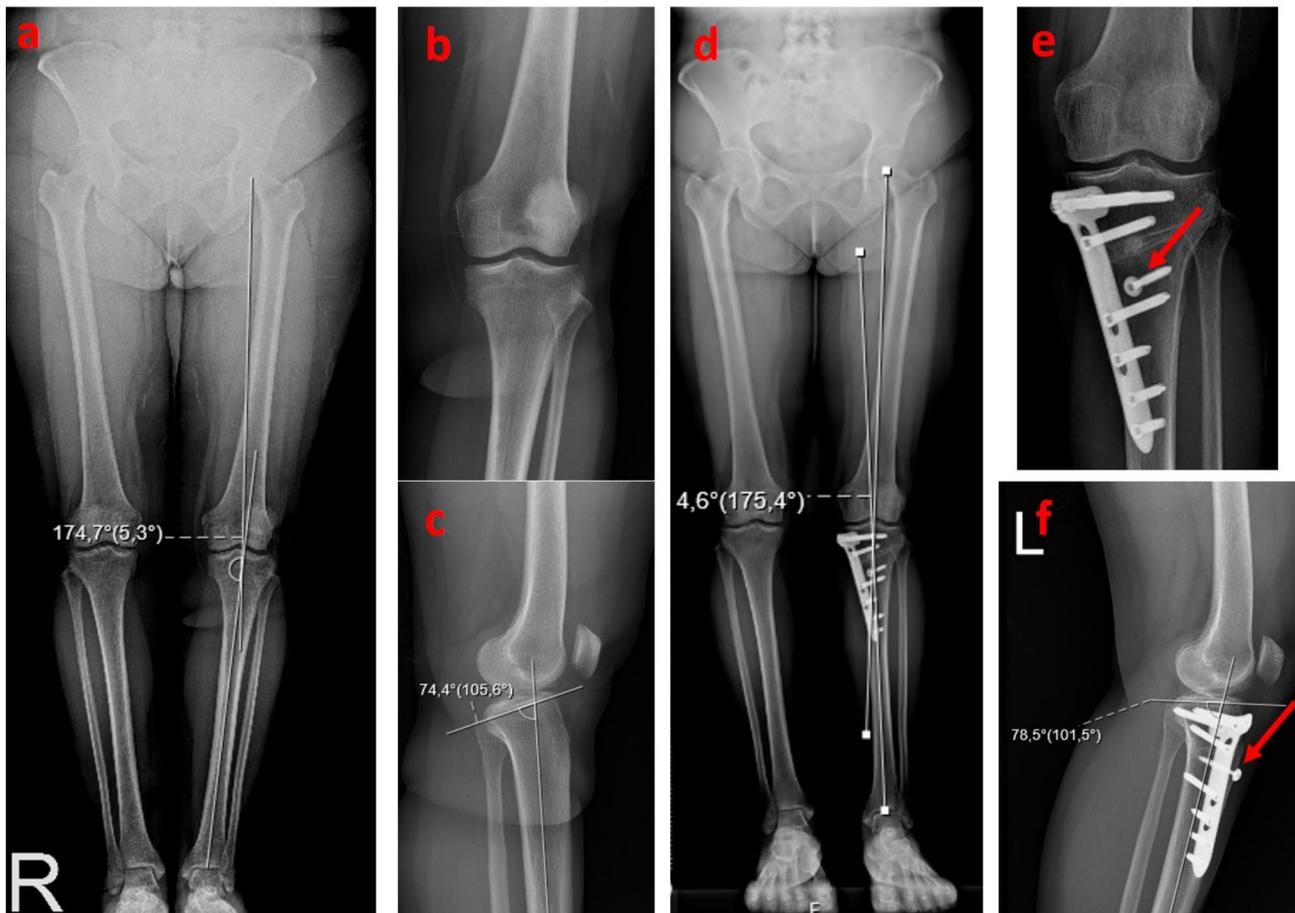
(a) Preoperative weight-bearing full-leg length radiograph of a patient who had left medial meniscus root tear. Mechanical tibiofemoral angle of the left lower extremity was 5.3°. (b) Anterior-posterior radiograph of left knee. (c) Lateral radiograph of left knee. Posterior tibial slope was measured as 15.6°. (d) Postoperative weight-bearing full-leg length radiography after simultaneous medial meniscus posterior root repair and posteromedial opening wedge high tibial osteotomy. 4.6° of valgus alignment was measured. (e, f) Postoperative anterior–posterior and lateral views. The red arrows indicate the cortical screws used for pullout suture repair. Posterior tibial slope was measured as 11.5°
